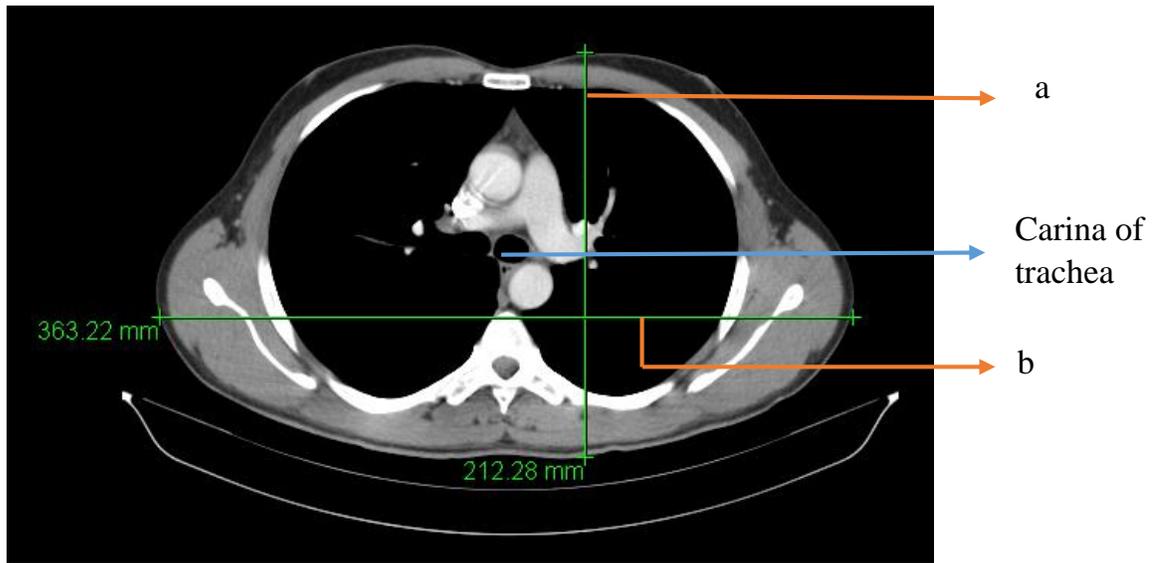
CT Thorax- Measurements of Tomographic Image- At Carina of Trachea- (Level T2)
